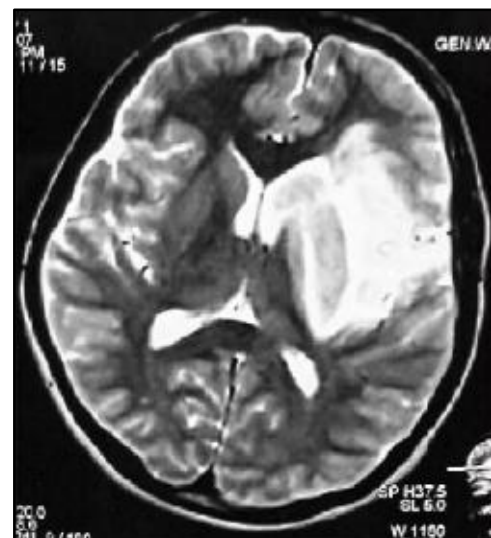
MRI Brain showing Acute Infarct in Left Middle Cerebral Artery Territory
